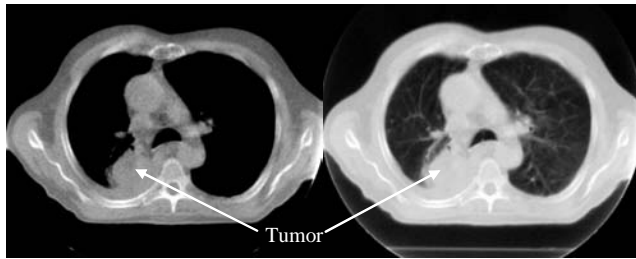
Verification CT of a lung patient. The panel on the left is a soft-tissue window and the panel on the right is a lung window. The difference between muscle and fat and bone and soft tissue is clearly distinguishable. Some of the vascular structures are visible in the lung. The tumor boundary in the lung is discernible, but its extension into the mediastinum is not visible. The dose to the patient was ~3 cGy.
